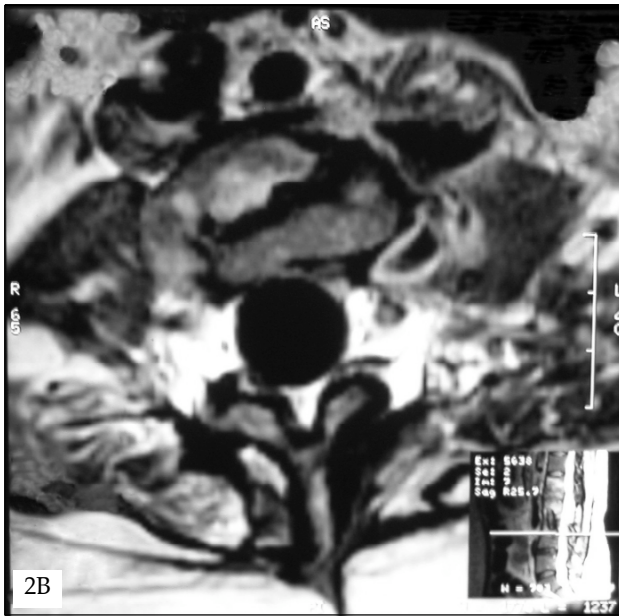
Sagittal T1-weighted magnetic resonance imaging (MRI) section with gadolinium enhancement (A) showed L1, L2, L4 and L5 osteomyelitis and L1-2 discitis. In axial T1-weighted MRI section with gadolinium enhancement at L3 level (B), it was seen that infection reached to the anterior implant; and axial T1-weighted MRI section with gadolinium enhancement at L1-2 intervertebral disc level (C) showed spondylodiscitis.
